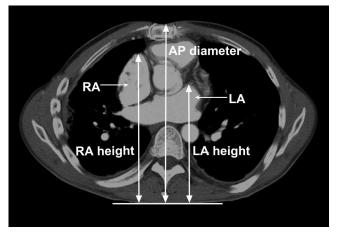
A chest computed tomography section showing right atrium (RA) height, the anteroposterior diameter of the thorax (AP diameter), and left atrium (LA) height. Although all parameters are displayed on the same section for explanation, each parameter may have been measured on different computed tomography sections.
